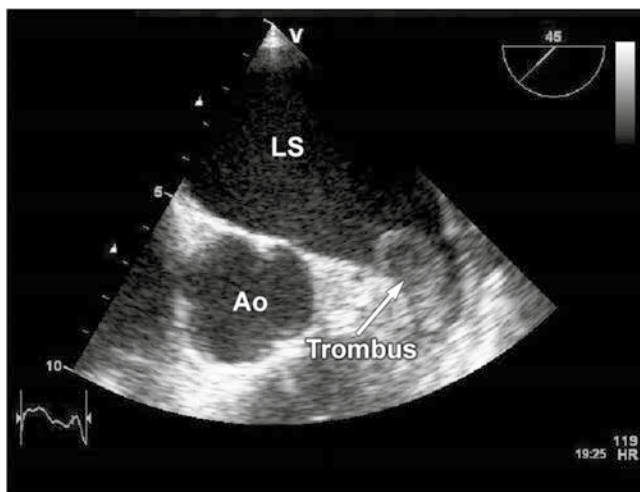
Preprocedural transesophageal echocardiogram in a patient with long term persistent AF, depicting thrombus in the left atrial appendage (arrow) despite previous anticoagulation therapy with INR above 2.
